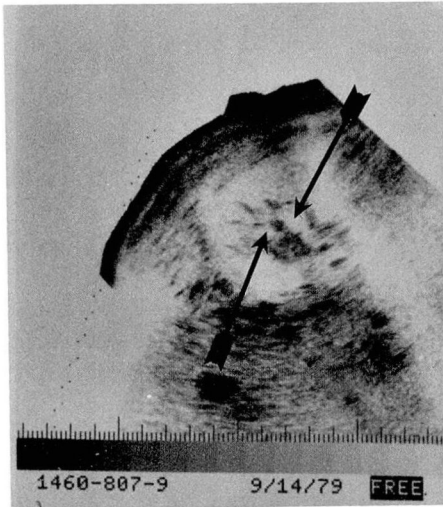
A, (top left) Transverse ultrasonic view of the left kidney with urinary tract obstruction and papillary necrosis. Note the lucent (white) round areas (arrows), which represent dilated renal calyces and infundibuli. B, (top right) Longitudinal ultrasonography of same kidney; an irregular dilated calyx is identified in the upper pole of the left kidney (arrow), which corresponds to the area of papillary necrosis that has left an area of dilatation in the upper urinary collecting system. C, (bottom left) Retrograde pyelogram after catheter withdrawal. Note dilated pelvis and irregular calyces of left kidney and the dilated left ureter with filling defect in its distal third (arrow).
